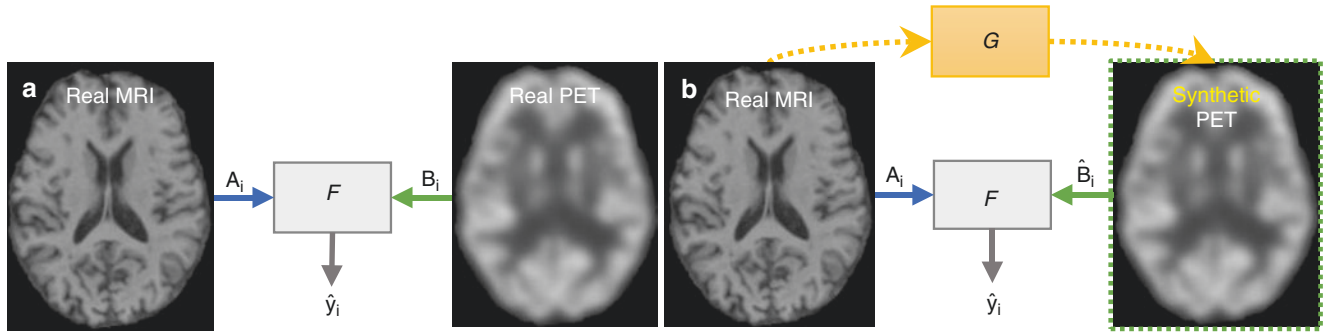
(a) A diagnosis model F trained on the complete MRI and PET scans. (b) A diagnosis model F trained on the complete (after imputation for missing PET scans) data. A_i and B_i represent the MRI
